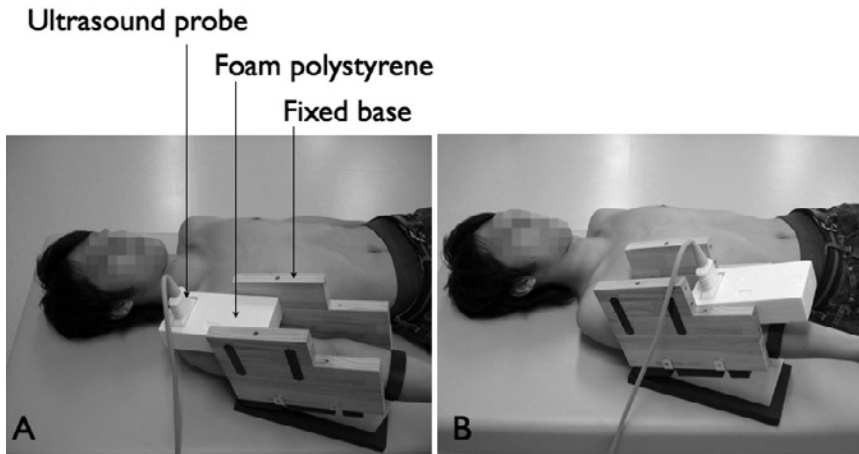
Subject positioning for scanning ultrasonography of the (A) proximal and (B) distal humerus.
